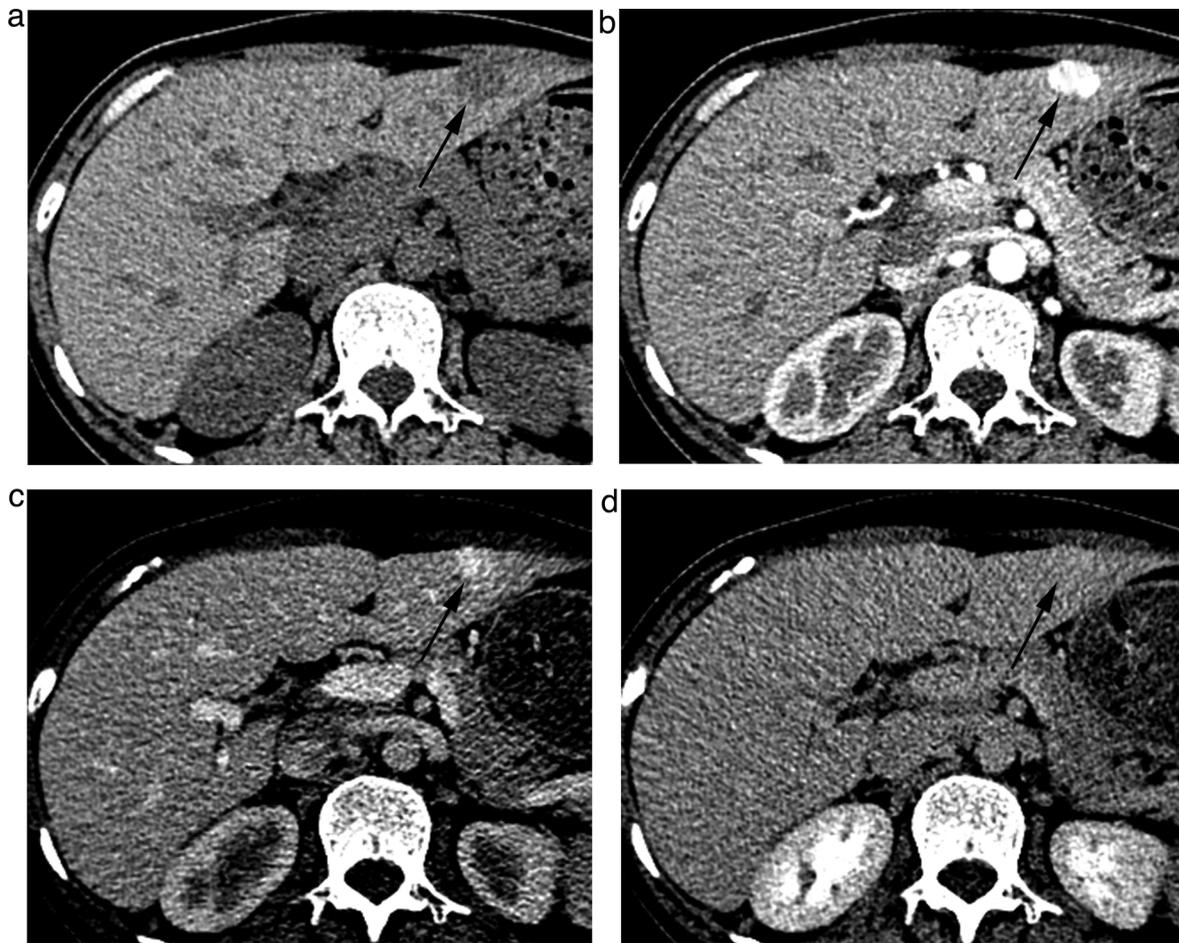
HH with type III dynamic enhancement appearance. (a) No-enhanced axial CT image shows a low-density lesion (arrow) in segment III. (b,c,d) Multiphasic contrast-enhanced CT images show early homogeneous enhancement of the lesion during the hepatic arterial phase (arrow, b), persistent enhancement during the portal venous phase (arrow, c), and isoattenuation relative to enhancing liver parenchyma during the parenchymal phase (arrow, d).
